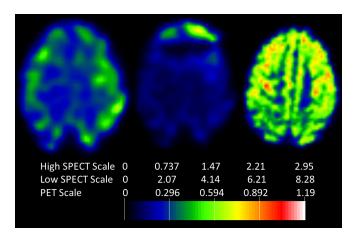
Axial section of reconstructed images. From left to right: high and low level ictal SPECT and interictal PET studies. Same slice in axial view is shown in Fig. 3 to 6.
